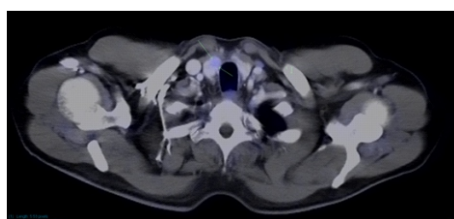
Axial fused ^{18}F -PSMA PET/CT image showing focal mild PSMA uptake in the right anterior thyroid lobe. This was subsequently diagnosed as papillary thyroid carcinoma with ultrasound guided FNA. No evidence of PSMA avid nodal or metastatic disease.
